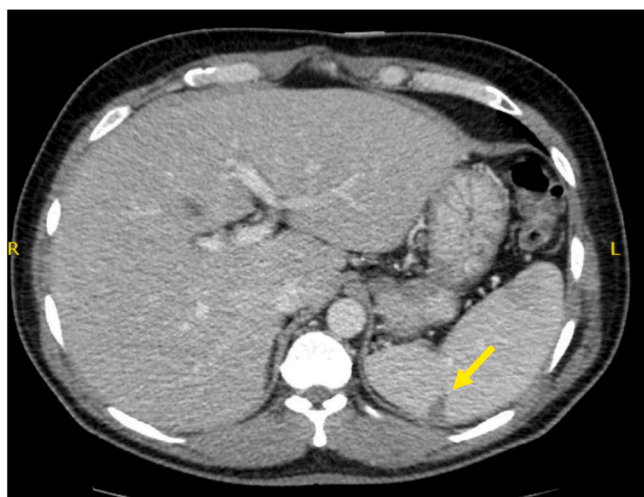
Splenic infarct in Q fever. Computed tomography of the abdomen and pelvis with intravenous iodinated contrast demonstrating wedge-shaped hypo-enhancing lesion in the spleen (indicated by the yellow arrow).
